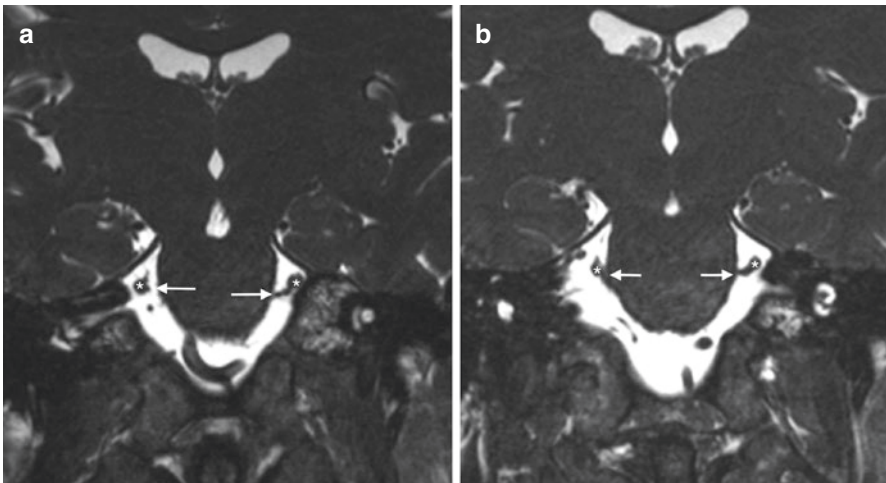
Coronal T2-weighted SSFP images show the trigeminal nerves at their mid-cisternal segments (a) and more posteriorly near the root entry zones (b). A single branch of the right superior cerebellar artery (SCA) borders the medial aspect of the right CN V along its cisternal segment (right arrow, a) and persists at this location at the root entry zone (left arrow, b). Similarly, paired SCA branches medial and inferior to the left CN V along its cisternal segment (left arrow, a) also track along the root entry zone (left arrow, b)
